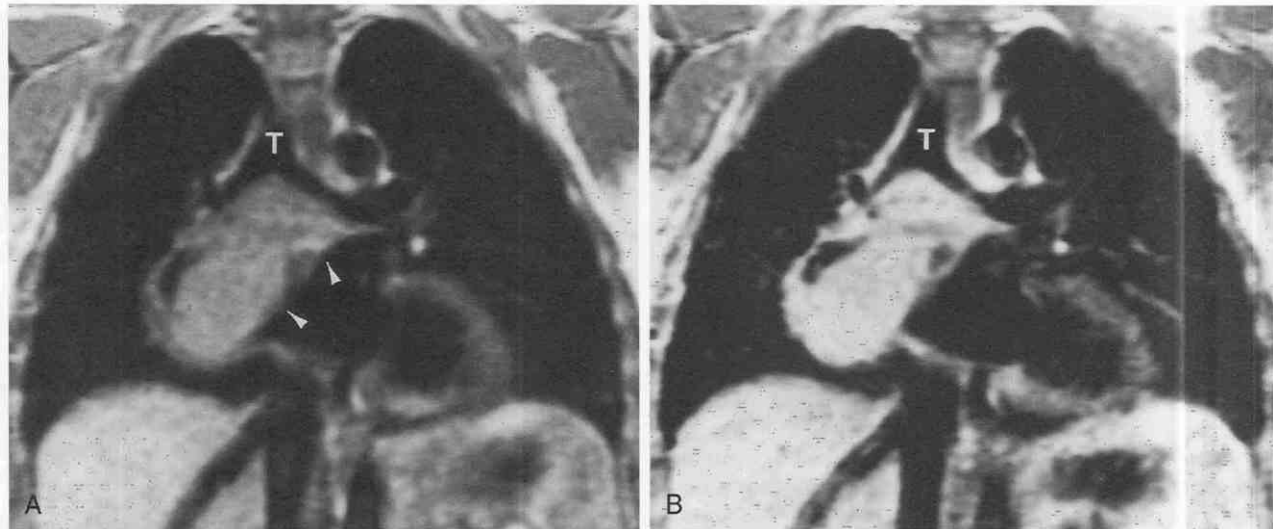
Hyaline-vascular Castleman's disease. A, Coronal T1-weighted MR image shows large, homogeneous mass (arrowheads) in subcarinal region of intermediate signal intensity. Note mass effect on the carina. B, Coronal T1-weighted MR image following administration of gadolinium-based contrast material demonstrates diffuse enhancement within the mass, typical of hyaline vascular Castleman's disease. T, trachea.
